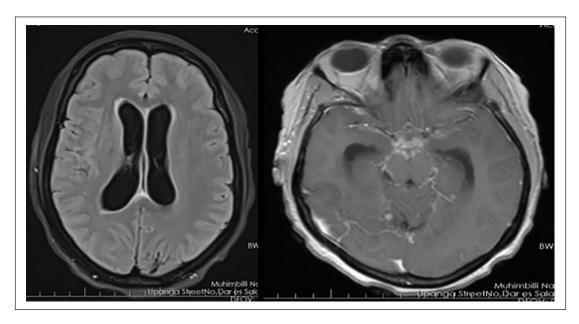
Non-contrast brain CT showing effacement of cerebral sulci and basal cisterns consistent with brain edema. There was leptomeningeal enhancement marked in the right occipital lobe and the cerebellum. CT: computed tomography.
